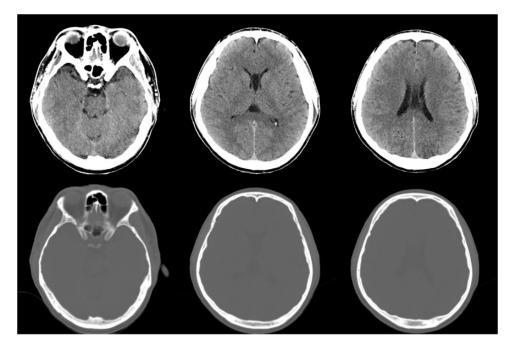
Non-contrast brain computed tomography revealed no abnormalities.
